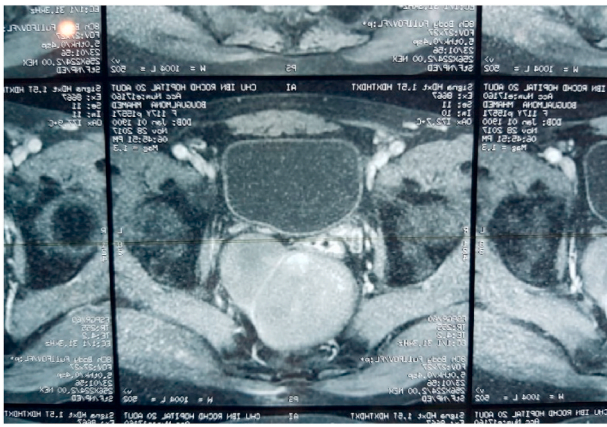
MRI showing a retrorectal tissue mass in T1 hypointensity.
